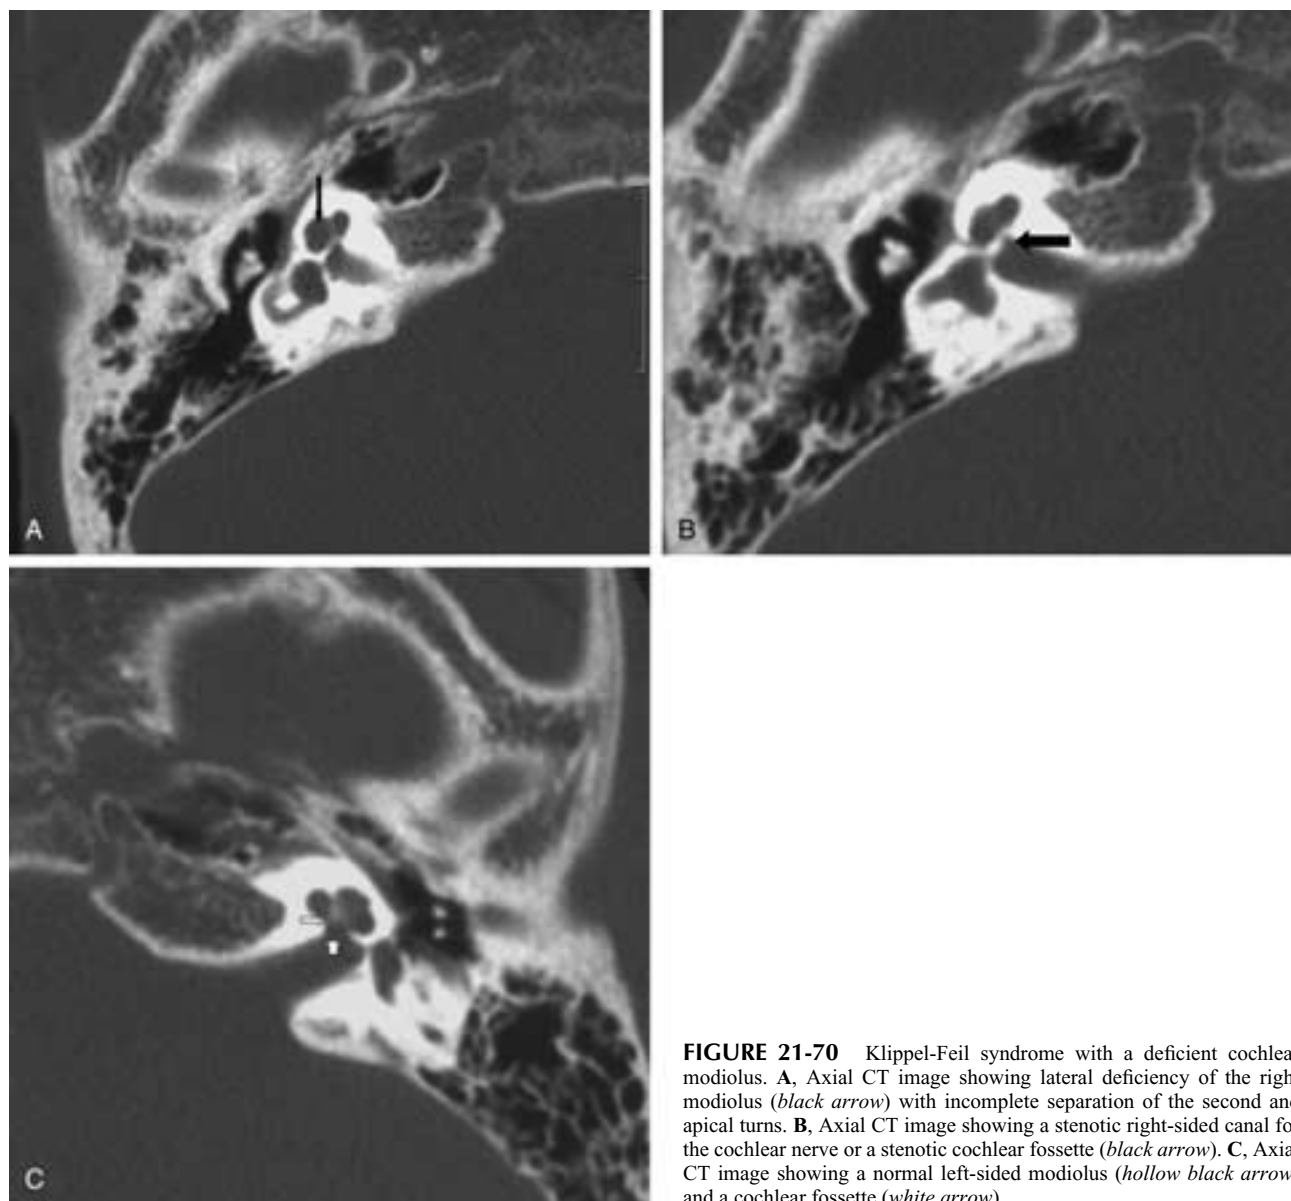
Klippel-Feil syndrome with a deficient cochlear modiolus. A, Axial CT image showing lateral deficiency of the right modiolus (*black arrow*) with incomplete separation of the second and apical turns. B, Axial CT image showing a stenotic right-sided canal for the cochlear nerve or a stenotic cochlear fossette (*black arrow*). C, Axial CT image showing a normal left-sided modiolus (*hollow black arrow*) and a cochlear fossette (*white arrow*).
